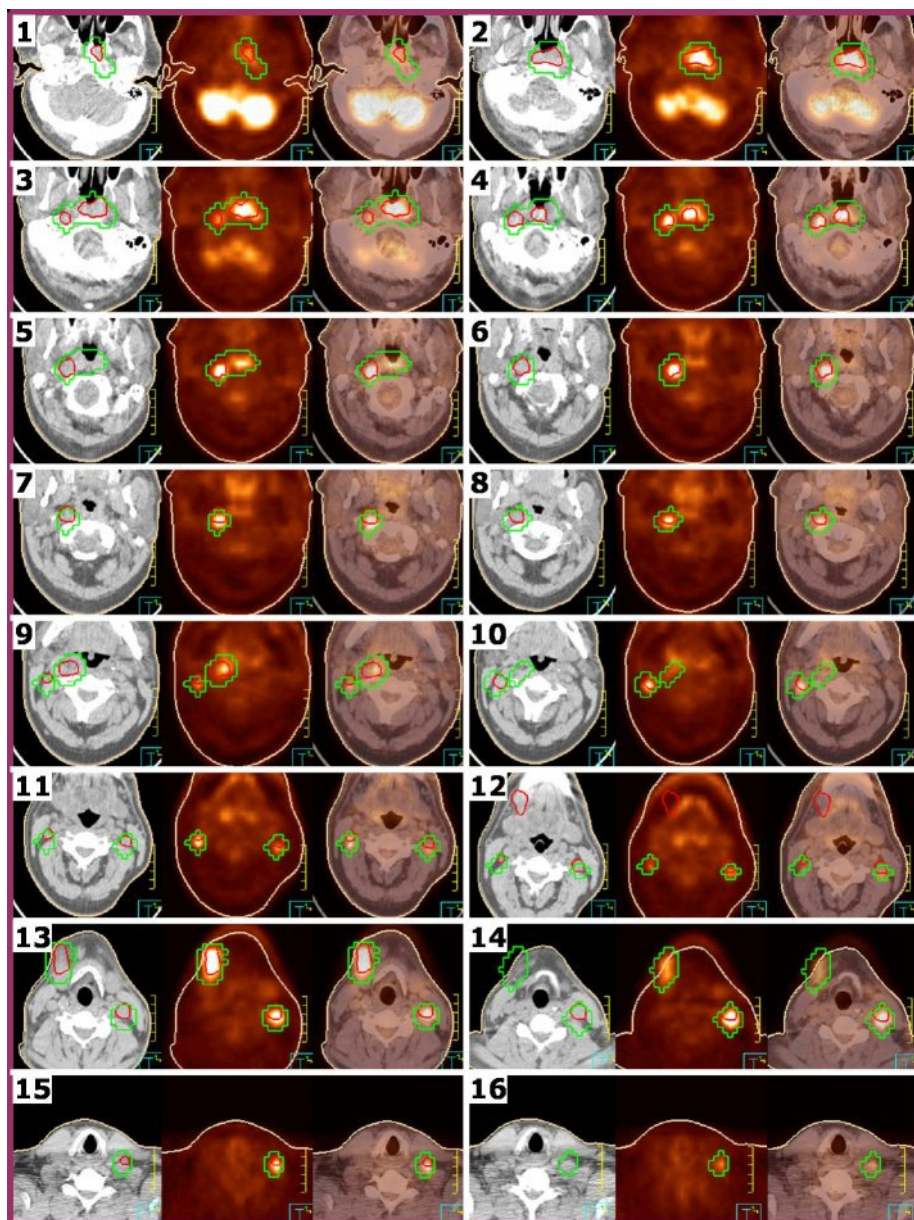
A series of CT, PET, and fused PET/CT transaxial slices for H&N case two showing the radiologist-delineation (green), oncologist-delineation (red) and the patient's outline (light-brown).
